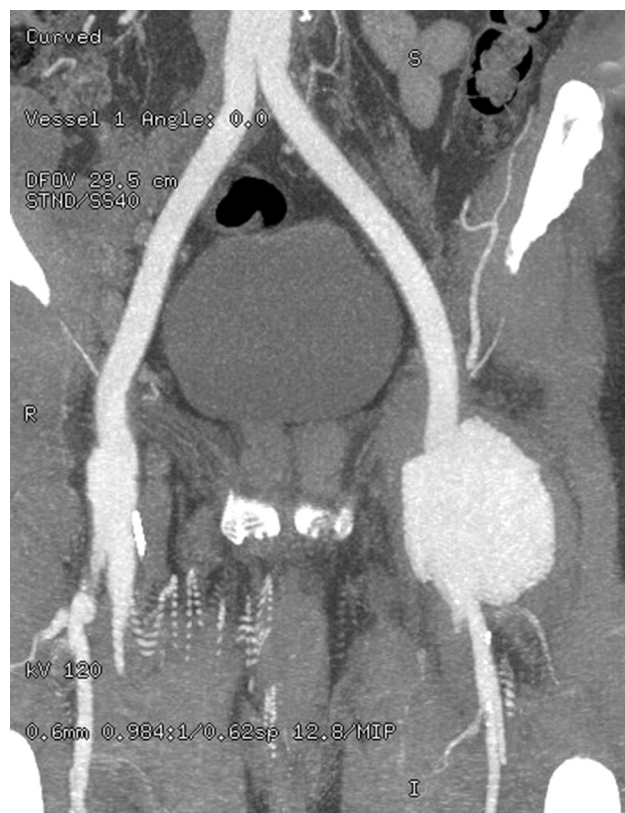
CTA indicating the 70 mm left femoral pseudoaneurysm.
